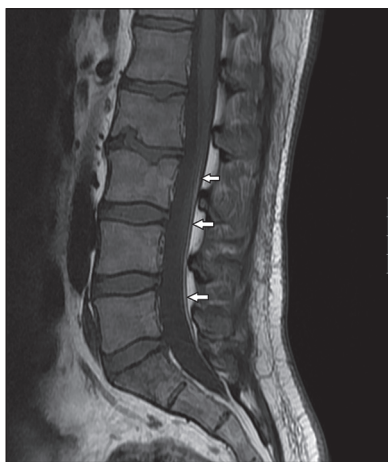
Sagittal T1 weighted MRI image demonstrating FFT as a long slack cord like hyperintense intrathecal structure isointense to the subcutaneous fat in patient 1
